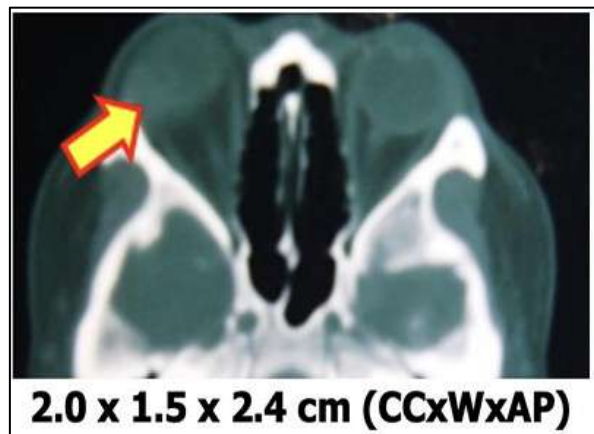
Plain Orbital CT-scan in axial view showing a heterogenous extraconal lesion adjacent to the right lateral rectus and lacrimal gland without involvement of the optic nerve, measuring 2.00 cm x 1.50 cm x 2.40 cm (yellow arrow)
